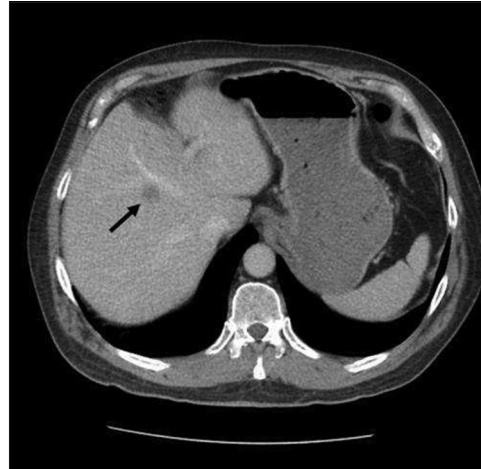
CT abdomen/pelvis demonstrates a hypodense hepatic lesion (arrow) concerning for metastatic disease.
